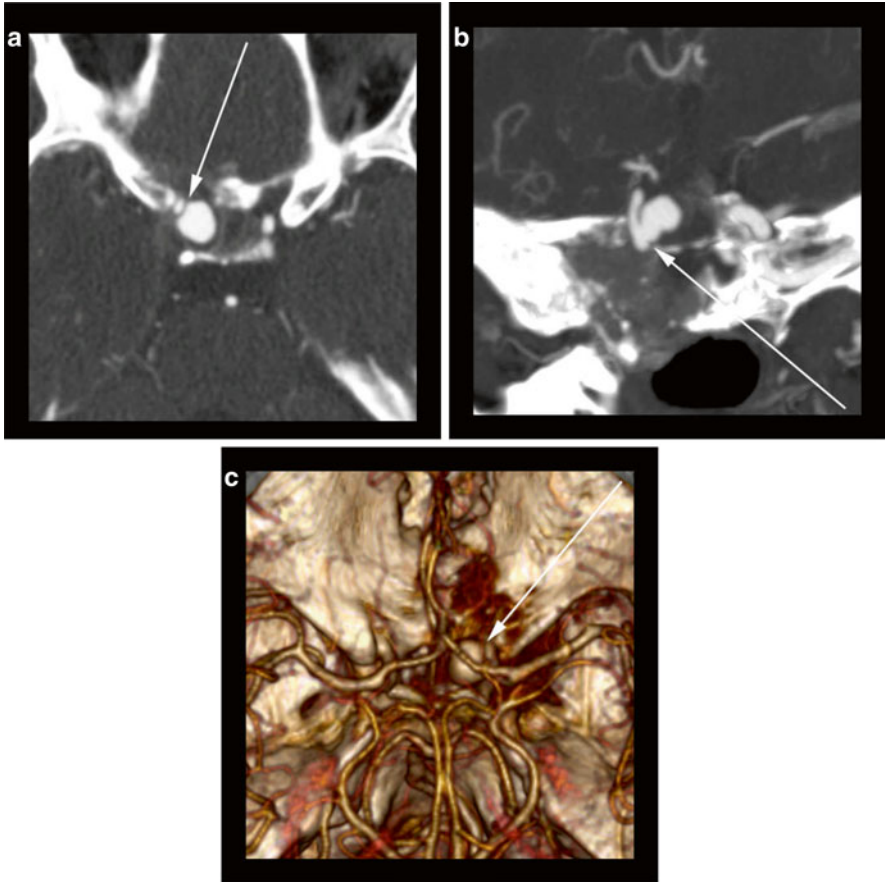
55-year-old with history of recurrent invasive nasopharyngeal carcinoma. (a) Axial CTA image reveals a saccular aneurysm arising (*arrow*) from the communicating segment of the right internal carotid artery just distal to the ophthalmic segment. The “raw” axial image at the level which best shows the aneurysm does not reveal the aneurysm neck or display the origin. (b) An oblique coronal CTA MIP reveals the irregular shape of the aneurysm neck (*arrow*) along with the relationship of the aneurysm to the parent vessel. (c) A craniocaudal view of a 3D volume rendering allows for visualization of the aneurysm (*arrow*) along with providing anatomic information about the surrounding structures. These types of views can be extremely helpful for pre-procedure planning
